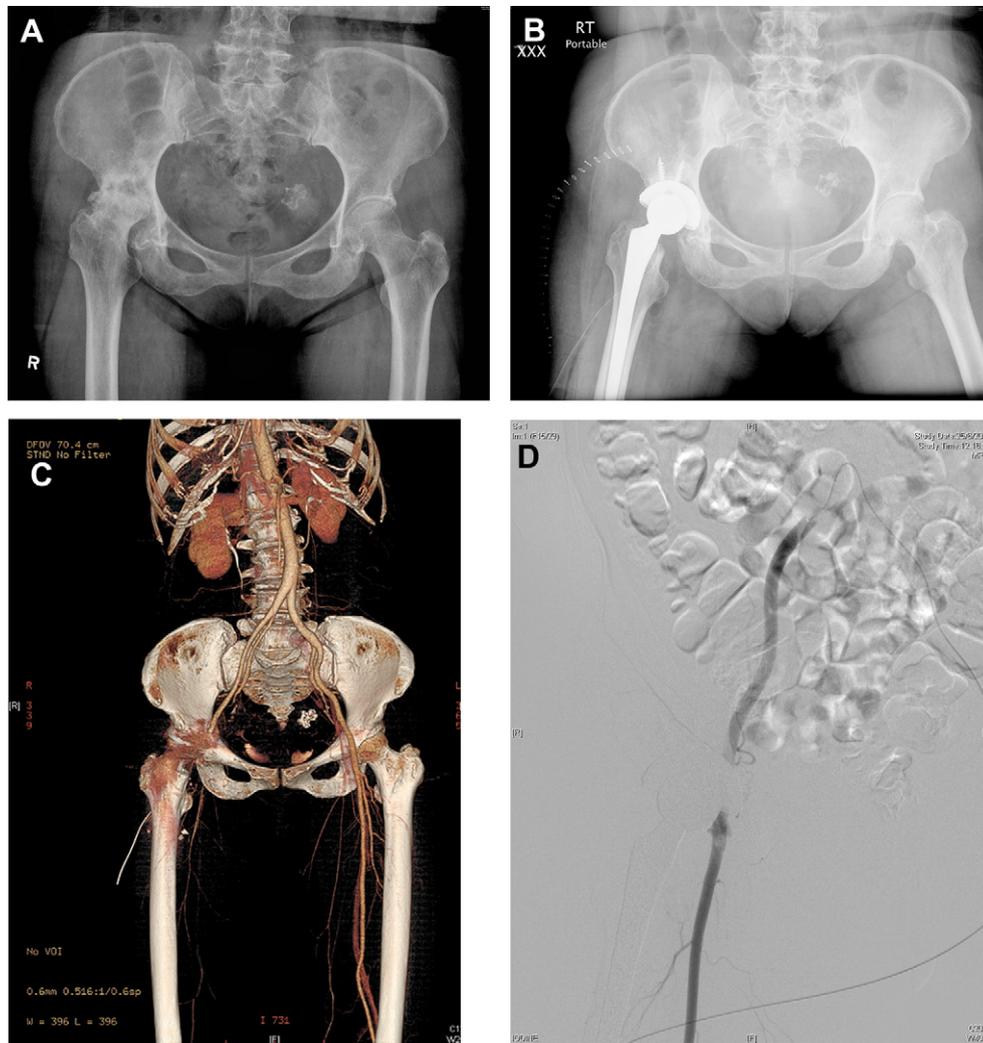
The radiographs show (A) secondary osteoarthritis of right hip from past septic arthritis and (B) the hip after cementless total hip arthroplasty was performed. (C) Computed tomography angiogram revealed filling defect of right superficial and common femoral arteries without good collateral circulation. (D) The angiogram showed no significant stenosis of the right superficial femoral artery but a significant stenosis of the occluded deep femoral artery after the thrombectomy.
